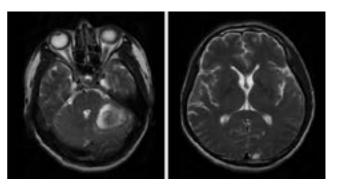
MRI revealed two abnormal circular enhanced intracranial masses with peritumoral edema
